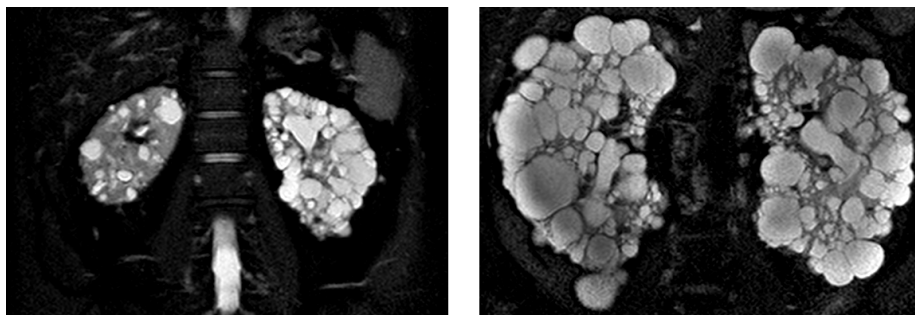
T2-weighted images of kidneys in ADPKD patients.
